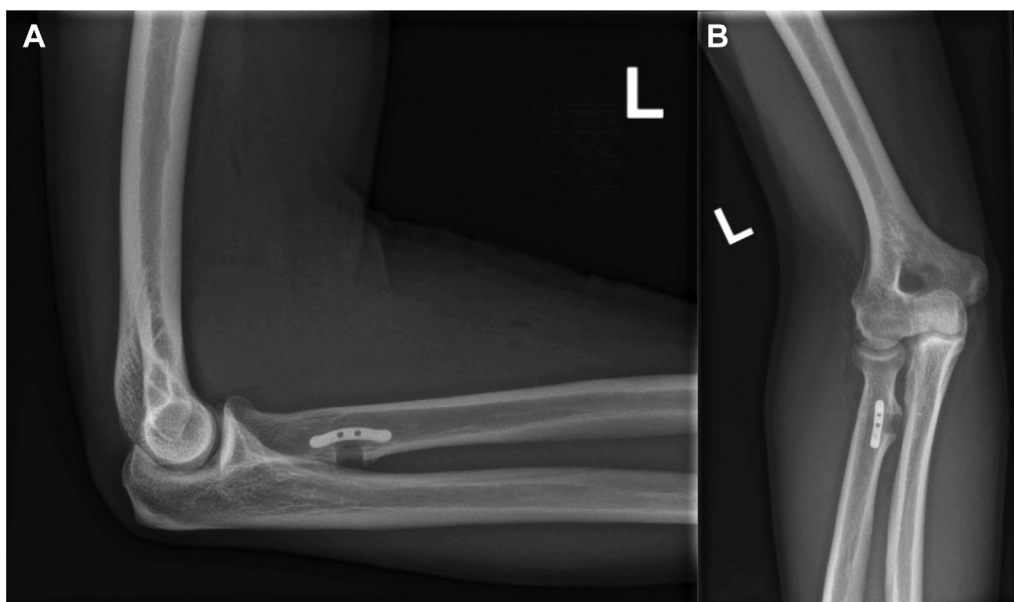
(A and B) Radiographic follow-up at 2 weeks. No signs of cortex breakthrough and centralization of the button at the drill hole.
